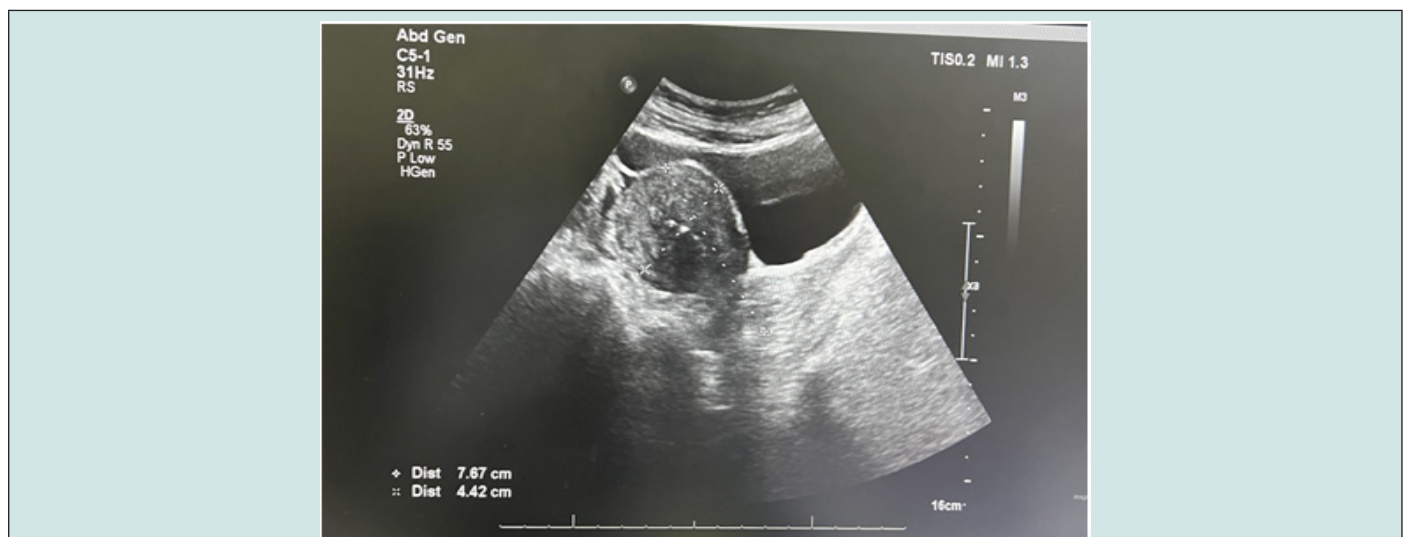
Pelvis Ultrasound revealed Heterogeneous myometrium with hypoechoic lesions.
